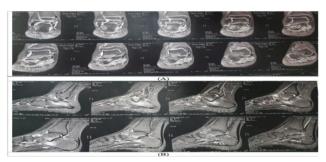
(A): Sagittal CT showing the absence of coalition; (B): Coronal CT showing the absence of coalition; CT: Computed Tomography.
